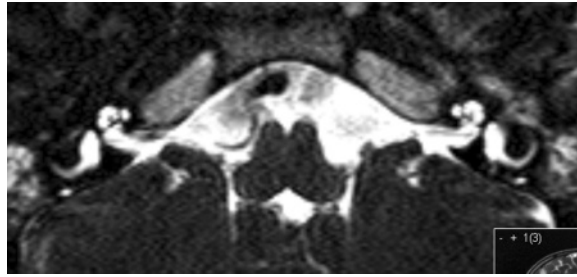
MRI scan demonstrating normal inner ear anatomy. Note the 'signet rings' of the lateral semicircular canals.
